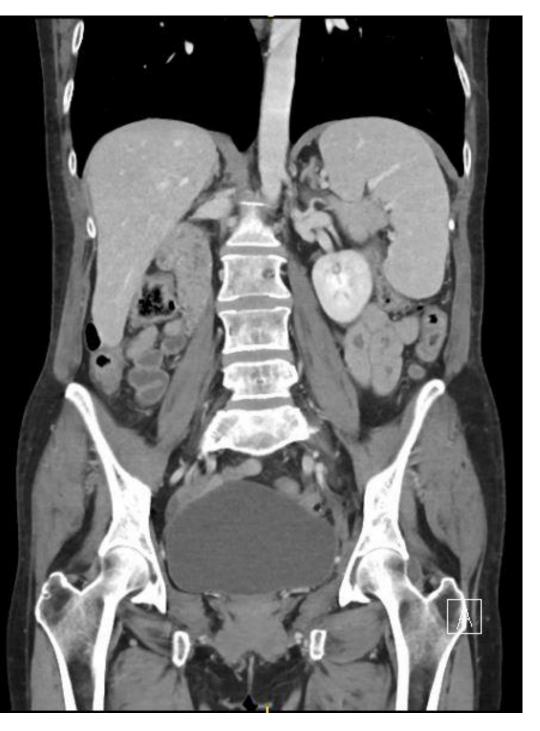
Admission CT scan demonstrating splenomegaly measuring 14 cm
